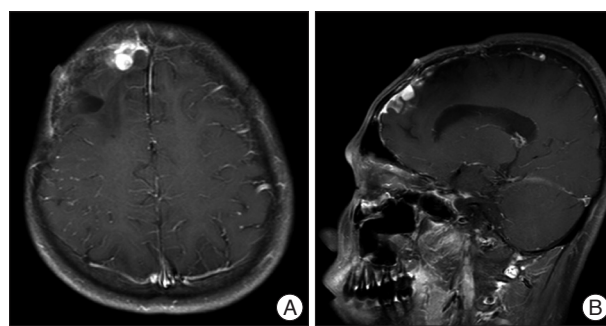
Brain MRI, 50 months after first operation. Axial (A) and sagittal (B) T1-weighted post-contrast image shows 1.0×1.0 cm sized well-defined enhancing nodule at right frontal convexity and leptomeningeal enhancement in right frontal area.
